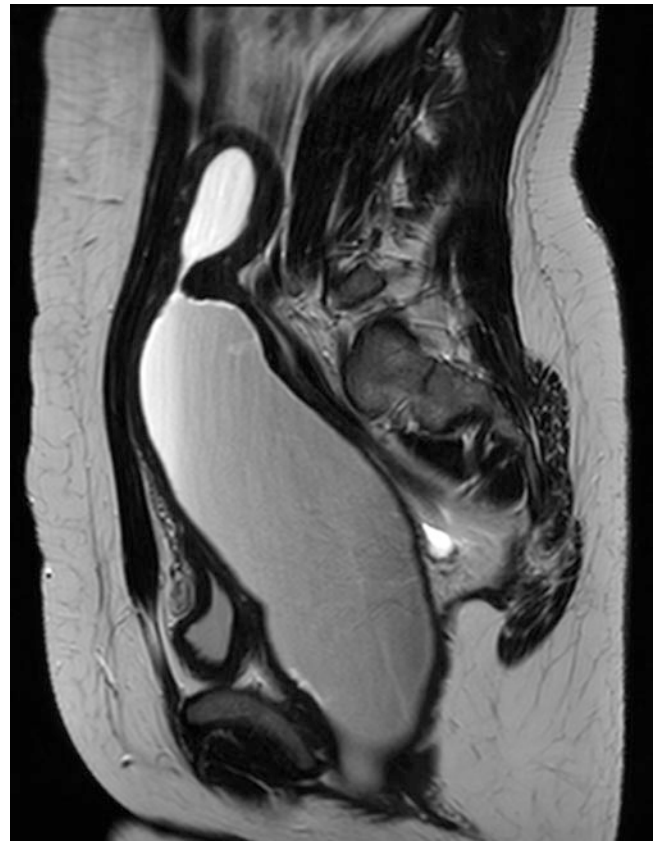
Sagittal T2-weighted MRI image demonstrating haematometrocolpos. High signal fluid distends the obstructed vagina and uterus. The low-volume bladder lies anterior to the massively distended vagina
